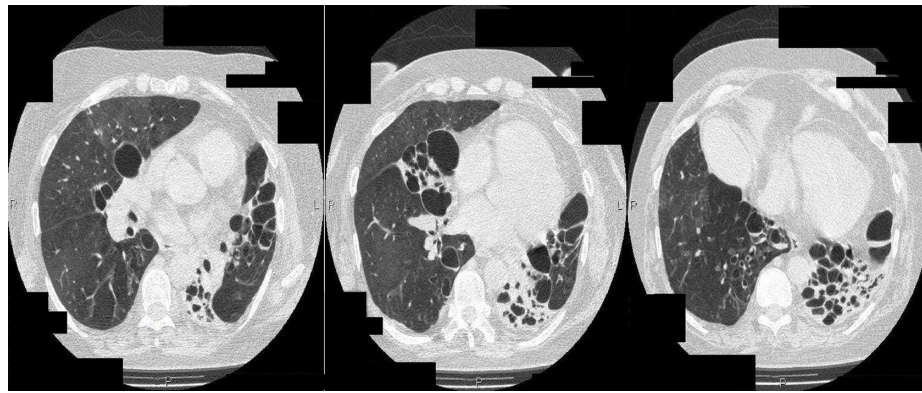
Sequential axial high-resolution computed tomography images of the upper, middle, and lower lung fields demonstrate multiple large and coalescent cystic bronchiectases, associated with volume loss. Some of the bronchiectases have air-fluid levels that are due to bronchial secretions.
